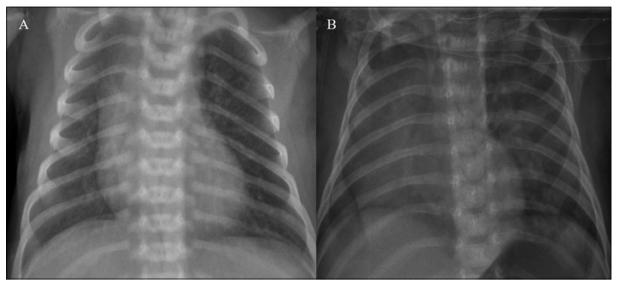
Case 2. X-ray of the case of right pulmonary branch agenesis. (A) At 2 weeks of life. No alterations are evident. (B) At 1.5 months. Here we can see the dextrocardialization and collapse of the pulmonary field itself.
